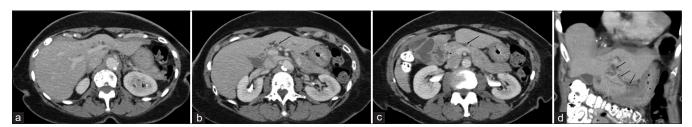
(a) Axial contrast-enhanced CT shows mildly prominent left hepatic bile ducts. (b) The left hepatic ducts converge intro the accessory common bile ducts (arrow). (c) The accessory common bile duct (arrow) is seen conversing over the pancreas, separate from the normal common bile duct (arrowhead). (d) Coronal CT shows the accessory common bile duct coursing along the pancreatic body and tail toward the lesser curvature of the stomach.
